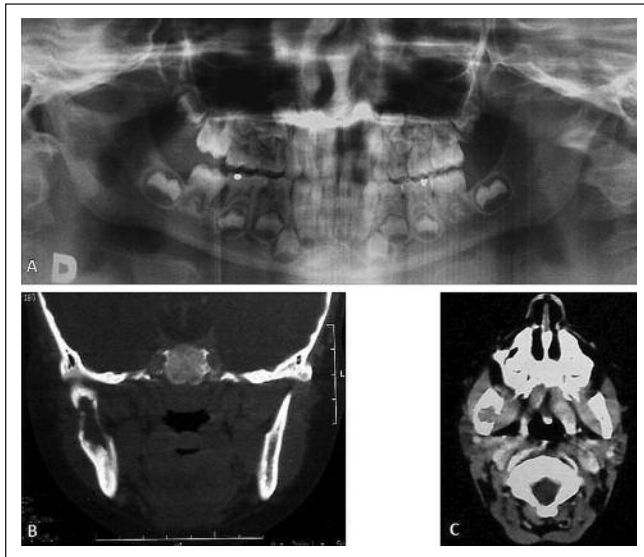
Radiography images showing a radiolucent area in the right mandibular ramus (A) and evidence of cortical fenestration (B, C).
